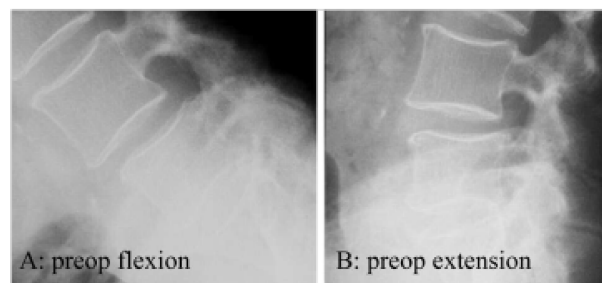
Lumbar X-ray Preoperative and postoperative.
